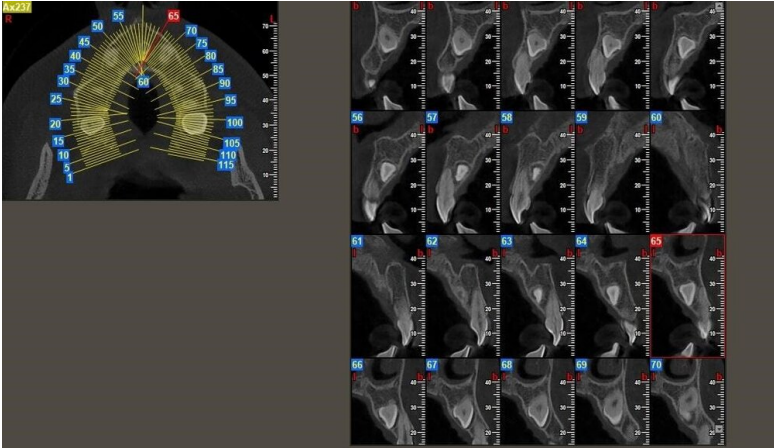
CBCT cross section
